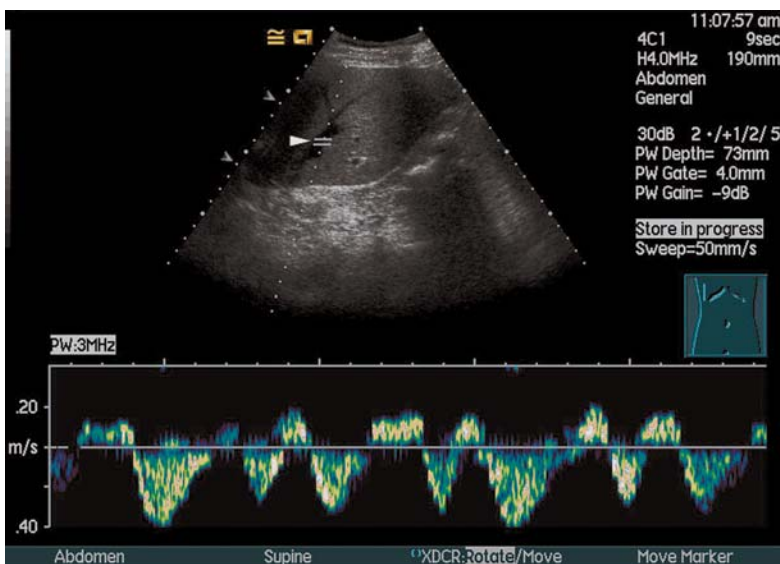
In this spectral Doppler tracing the sensitive gate has been placed over the middle hepatic vein (arrowhead) and the trace shows the normal pattern where the predominant flow towards the heart (shown below the line to indicate flow away from the transducer) is interrupted by reverse flow as blood is returned to the liver in cardiac systole
